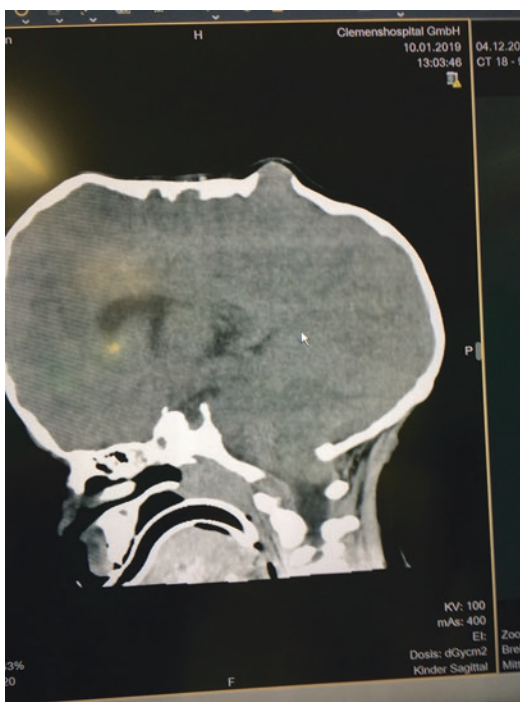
CBCT in a median view
